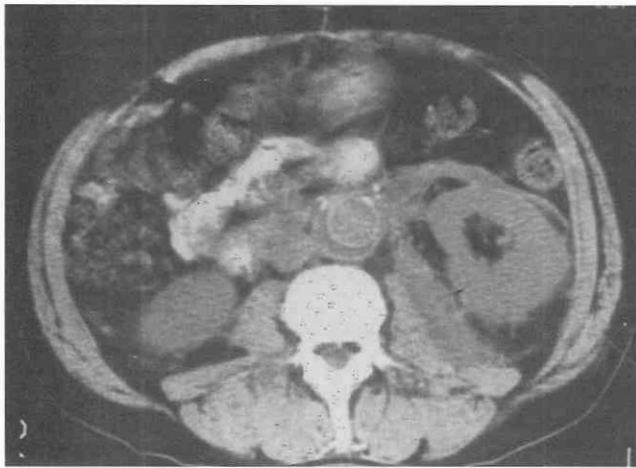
Endoaneurysmorrhaphy shortly after aortic aneurysm repair. Unenhanced CT scan demonstrates the partially calcified wall of the native aorta surrounding thrombus or perigraft fluid, which in turn surrounds the aortic graft. On this scan, the aortic graft is of higher attenuation than that of the blood in the aortic lumen. Extensive persistent hematoma from a recent aneurysm rupture in the retroperitoneum can be seen on the left.
